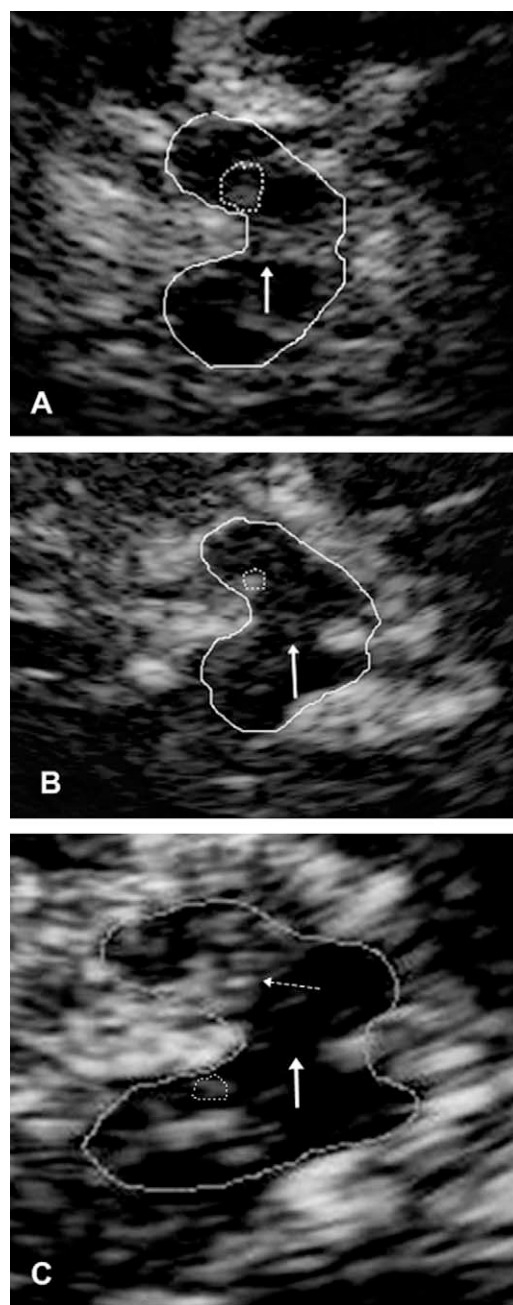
Sonographic images of corresponding midbrain axial sections in three subjects. The butterfly-shaped hypoechoic midbrain was encircled for better visualization (full line). Thick arrows indicate brainstem raphe; red nucleus is encircled with dotted line. (A) Mesencephalic brainstem of a healthy individual with normal, highly echogenic brainstem raphe as a continuous line which has the same echogenicity as the red nucleus. (B) Mesencephalic brainstem of a patient with unipolar depression with interrupted, reduced echogenicity of the brainstem raphe. (C) Mesencephalic brainstem of a PD patient with depression displays marked hyperechogenicity of the substantia nigra (thin dotted arrow) and invisible brainstem raphe (thick full arrow).
